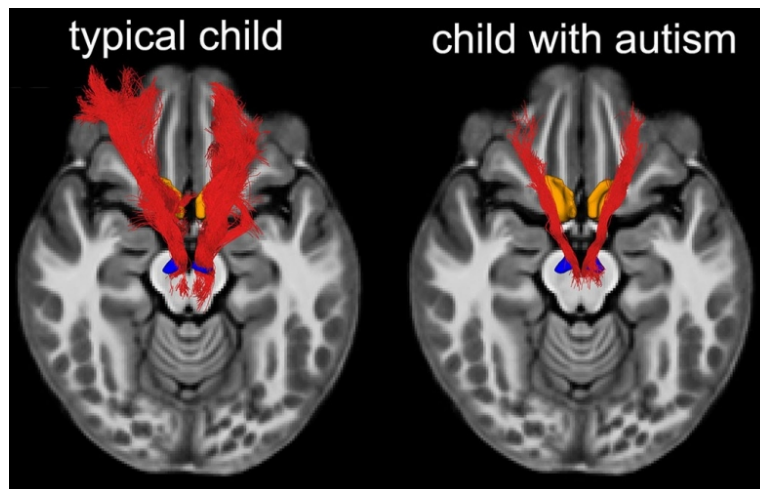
Reduced MR imaging signatures of NAc-VTA tracts in an ASD child compared to a typical, non-ASD child. Six control and six ASD subjects revealed that ASD subjects had lower density, and the reduction in density corresponded to increased severity of social deficits. Reproduced by permission of K. Supekar and E. Digitale, *Stanford Medicine*.
